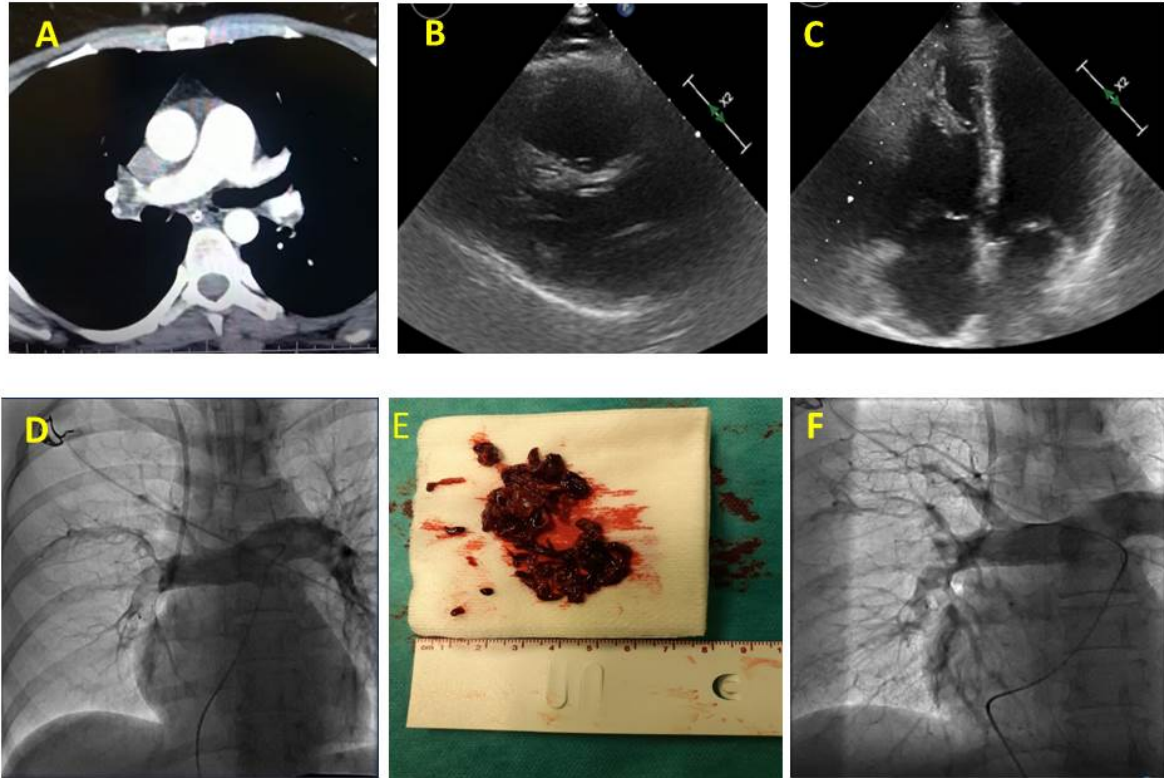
A. Computed tomography (CT): proximal clots in the main pulmonary arteries with almost total occlusion of the right pulmonary artery. B. 2D-echocardiography: right ventricle enlargement in long axis parasternal view. C. 2D-echocardiography : right ventricle enlargement in 4-chamber view. D. Pulmonary arteriography: huge proximal clots in right pulmonary artery and smaller clots in the left pulmonary artery. E. Huge thrombus removed from right pulmonary artery. F. Pulmonary arteriography: The final result — restoration of blood flow in right pulmonary artery
